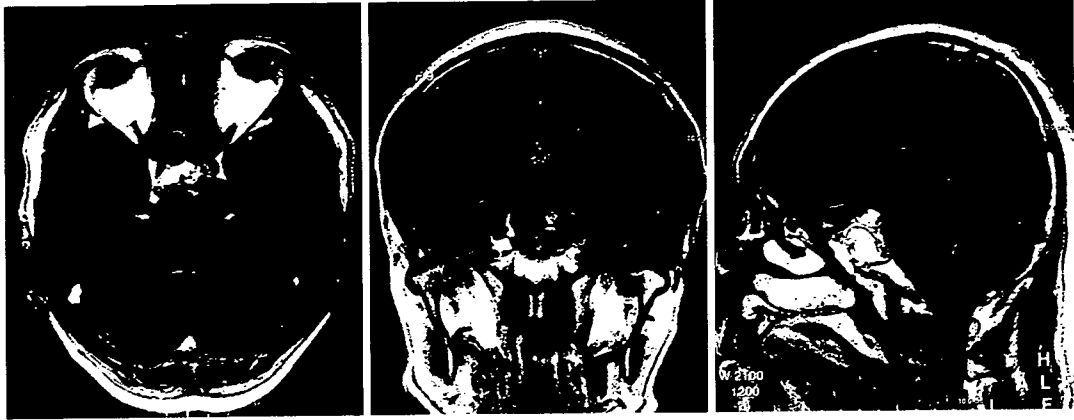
MRI (T1-Gd enhanced) after the second operation. The remaining tumor was shown in the left superior portion. It seems to be a blind corner with the endoscope that we use, because the endoscope is too short to see there.
